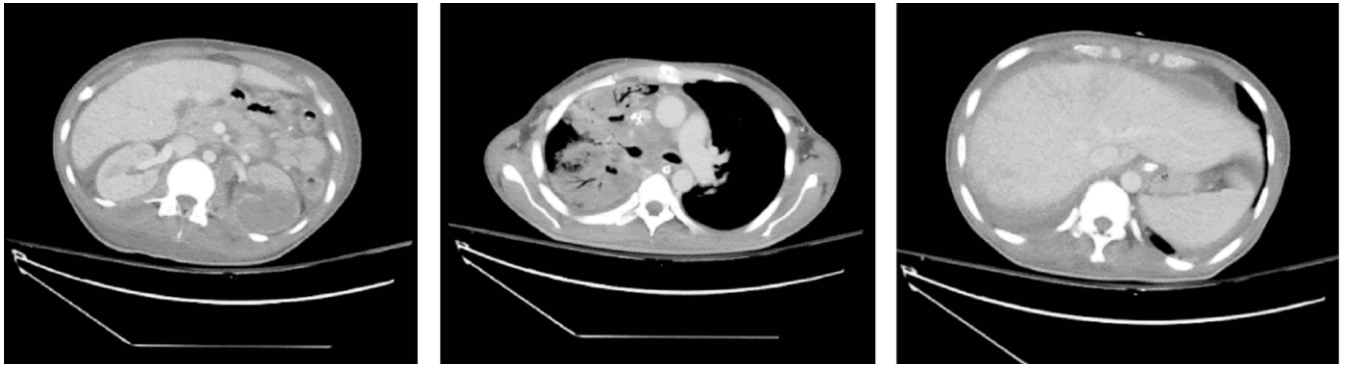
(a,b,c):- CT scan showing Multiple hypodense areas involving the left kidney, the right perihepatic region and right lobe of liver with Multi-lobulated peripherally enhancing lesions in the right hemithorax..
